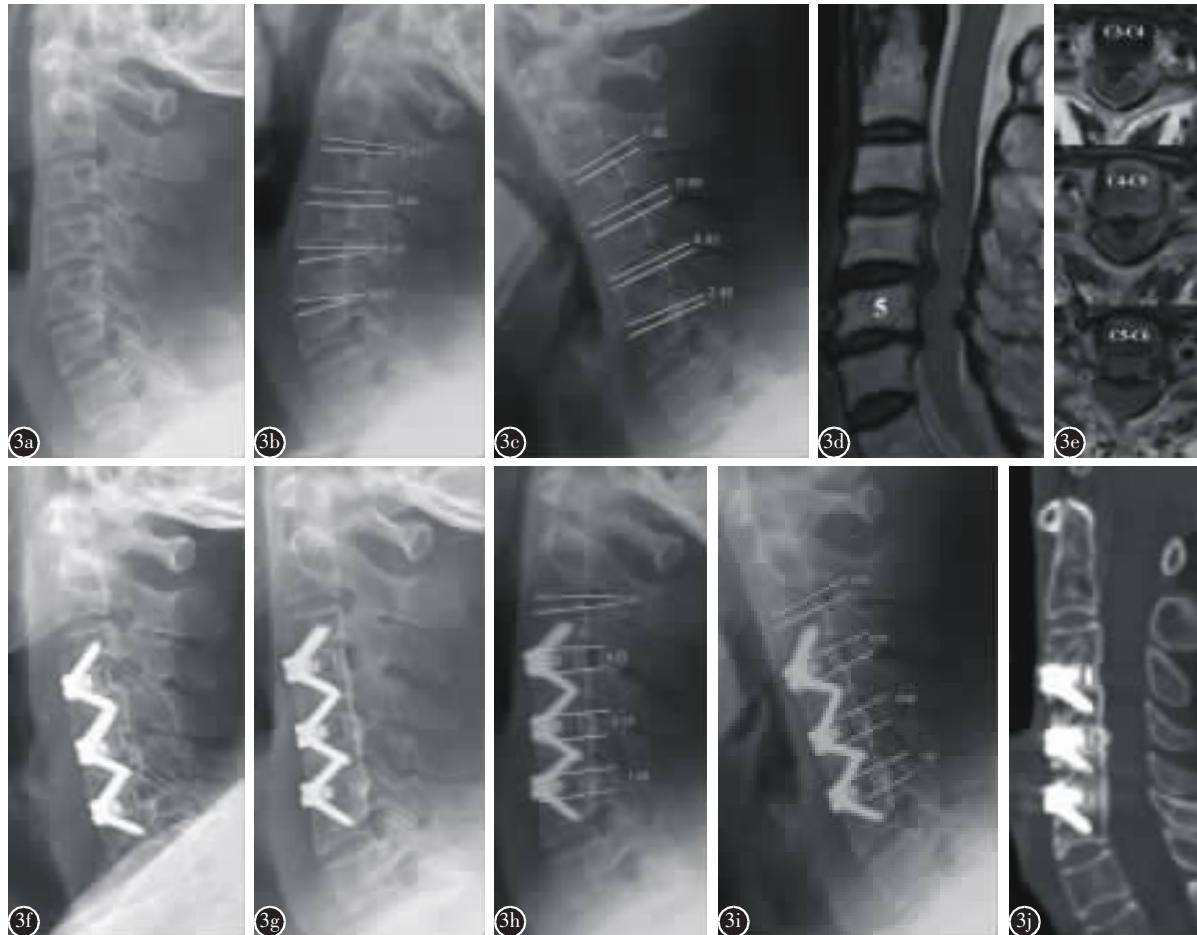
FFF 组典型病例,69岁女性患者 a 术前颈椎侧位 X 线片示 C2-C7 曲度为 19.79°,C3-C6 曲度为 13.12°,C4/5、C5/6 椎间隙后方骨赘形成,C5/6 椎间隙高度丢失 b,c 术前颈椎过伸过屈位 X 线片示 C2-C7 活动度为 31.44°,C3-C6 活动度为 22.78°,C2/3、C3/4、C4/5、C5/6 活动度分别为 5.28°、1.15°、8.03°、8.22° d,e 术前 MRI 示 C3/4、C4/5、C5/6 椎间盘突出,脊髓神经受压 f 术后 3d 颈椎侧位 X 线片示 C2-C7 曲度为 18.68°,C3-C6 曲度为 13.66°, 内固定位置良好 g 术后 15 个月颈椎侧位 X 线片示 C2-C7 曲度为 14.93°,C3-C6 曲度为 10.42°, 手术节段椎间隙后方连续骨小梁形成 h,i 术后 15 个月颈椎过伸过屈位 X 线片示 C2-C7 活动度为 11.50°,C3-C6 活动度为 1.88°,C2/3、C3/4、C4/5、C5/6 活动度分别为 7.15°、0.07°、1.10°、0.03° j 术后 15 个月颈椎矢状位 CT 示手术节段后方连续骨小梁形成
